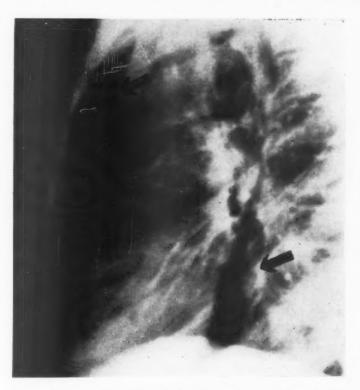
Left lateral roentgenogram also demonstrating pneumomediastinum.
